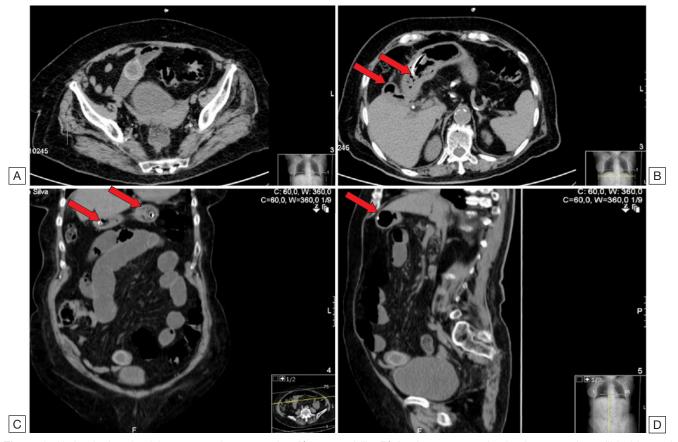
Abdominal and pelvic computed tomography: A) pneumobilia; B) fistulous communication between the gallbladder and the second portion of the duodenum; C) e D) impaction of a large stone in the distal ileum.
